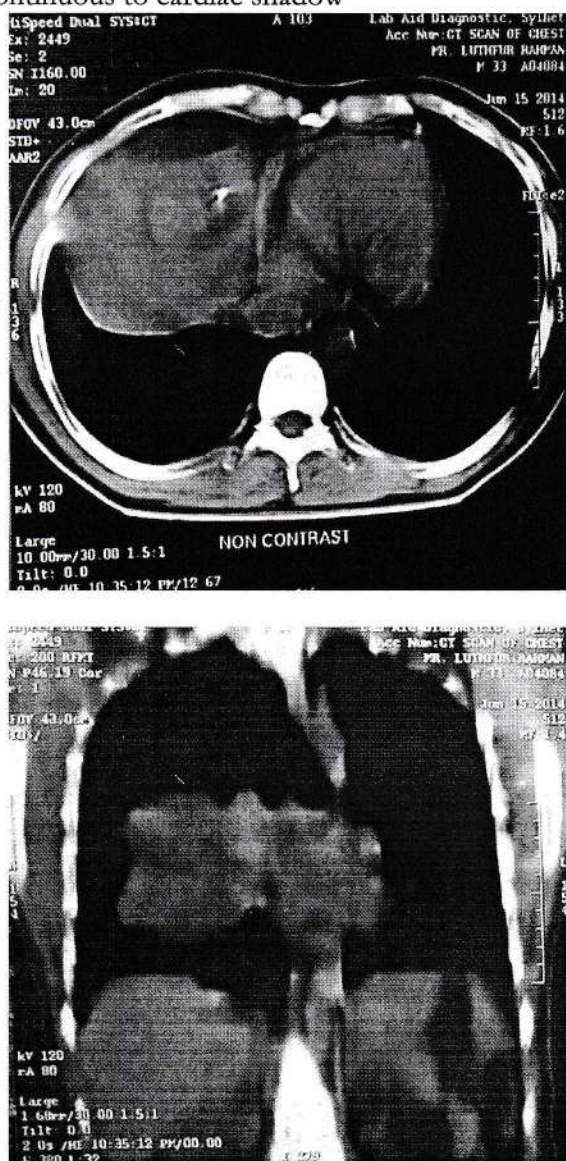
Computed tomographic scan showed a well defined cystic mass containing fatty tissue with fat-fluid level & calcifications, compressing the adjacent right lung. The mediastinal structures along with heart mildly shifted towards left.
